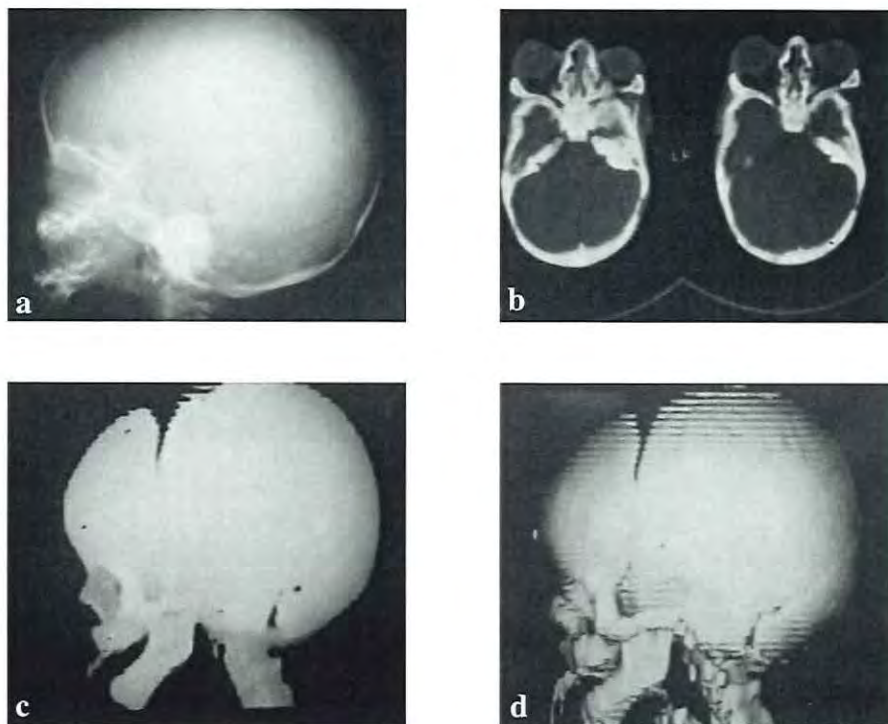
Imaging methods of an infant with Crouzon syndrome. (a) Lateral radiograph. (b) Axial CT scan. (c) 3D CT reconstruction. (d) 3D CT enhanced reconstruction.
